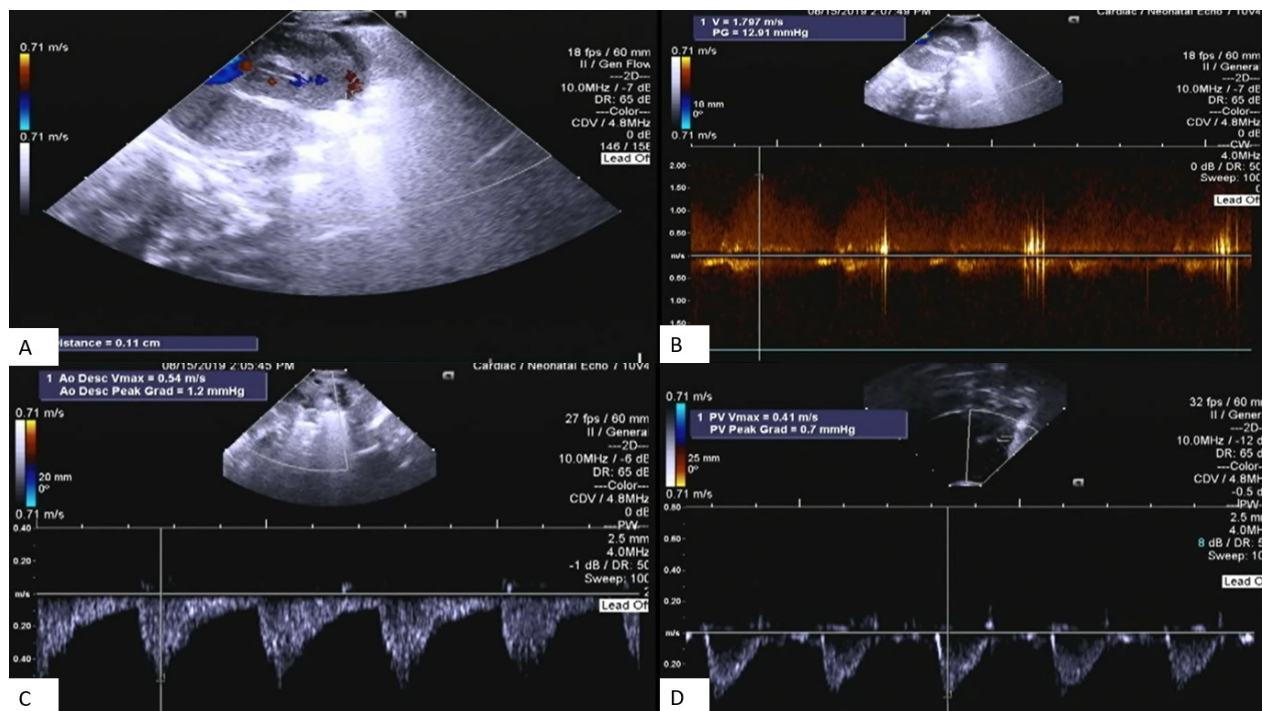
Transthoracic echocardiography images 24 hours after percutaneous closure of PDA. Pictures A and B show the PDA leak within the device measuring 0.11 cm with continuous Doppler signal of 13 mmHg. Pictures C and D show Doppler views in descending aorta and peripheral pulmonary artery, respectively. No pressure gradient was detected in descending aorta and peripheral pulmonary artery.
